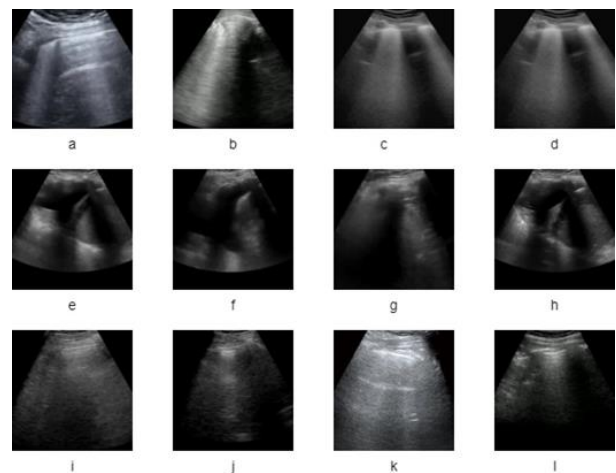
Sample lung ultrasound images obtained from POCUS dataset [4, 5, 6]. The first, second and third row represent COVID-19, Pneumonia and normal images, respectively
